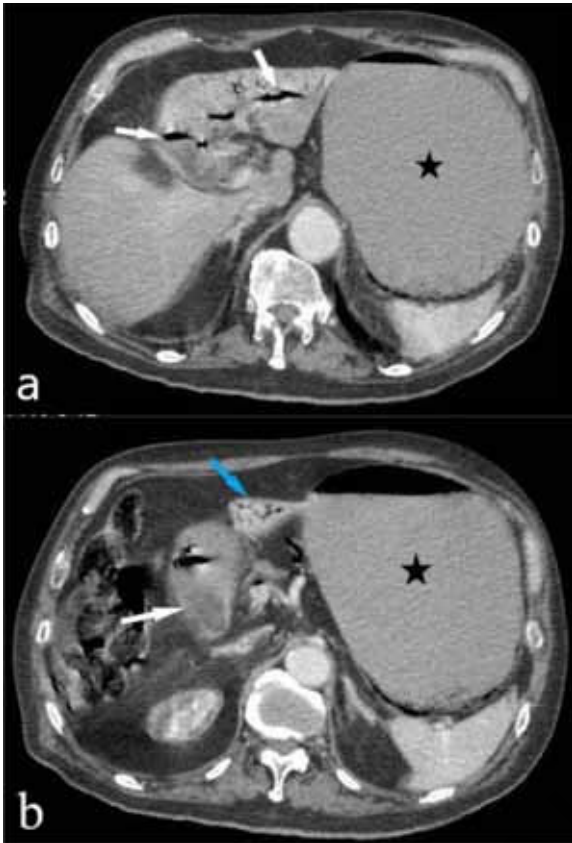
Contrast enhanced axial CT; A) Pneumobilia (white arrow) and gastric outlet obstruction appearance (black asterisk); B) Isodense lesion at duodenal bulb (white arrow), pneumobilia (blue arrow) and gastric outlet obstruction appearance (black asterisk).
